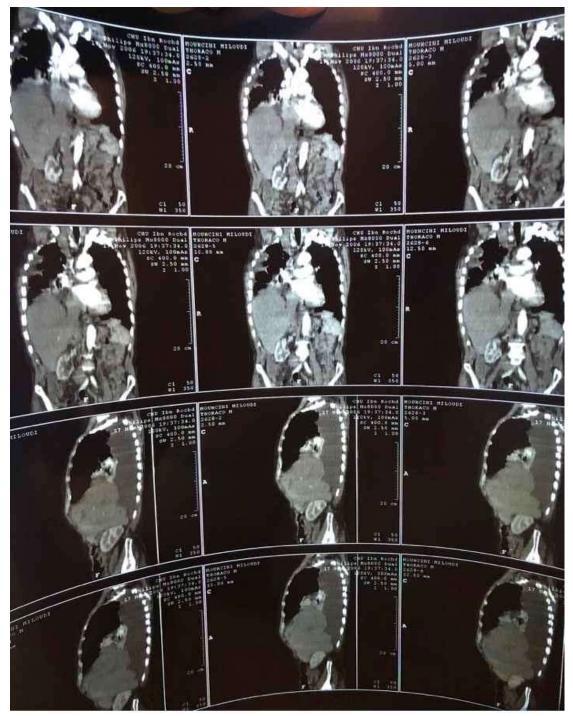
Coronal CT reconstruction confirming diaphragmatic defect and visceral displacement.
